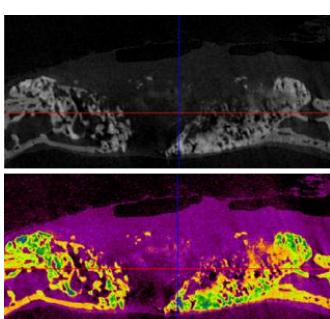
Micro CT images of hydrogel applied defects at 8 weeks. A. Hydrogel alone applied defect. B. Hydrogel+TAT-BMP-2 5 μ g applied defects. C. Hydrogel+TAT-BMP-2 2 μ g applied defect.
